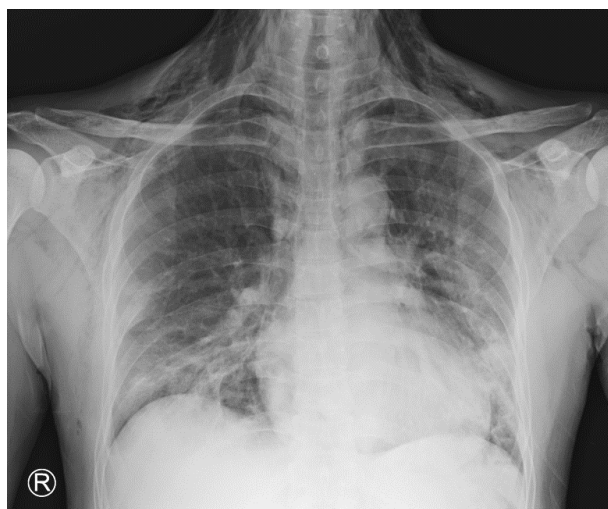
A chest X-ray taken on 15/08/2021 showed subcutaneous emphysema, pneumomediastinum, and pneumonia after the positive RT-PCR result from the previous day.
